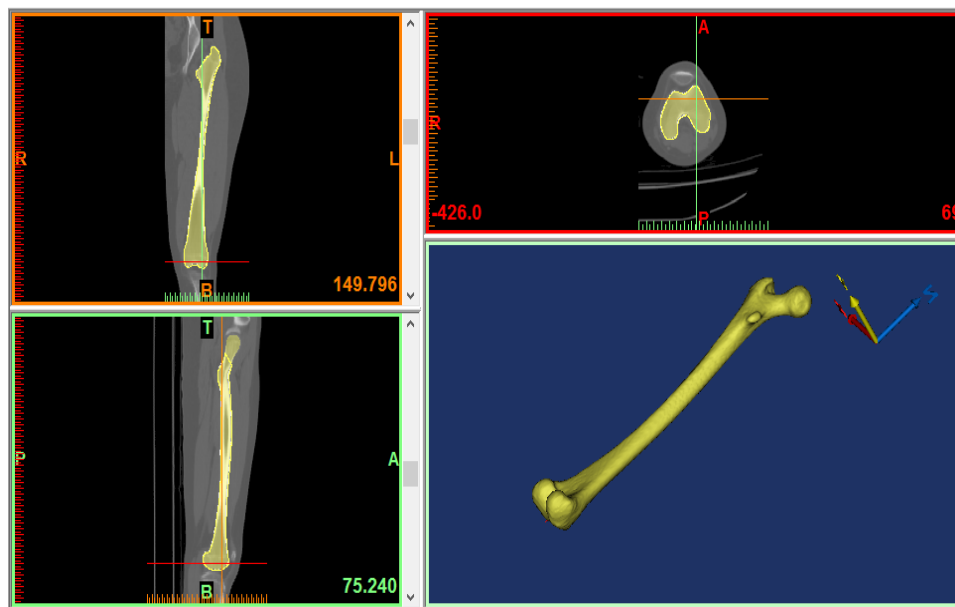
CT segmentations and Biofidel 3D solid modelling: Transverse (upper right), medial (upper left), frontal (lower left) and bone solid reconstruction of a patient femur (lower right)
